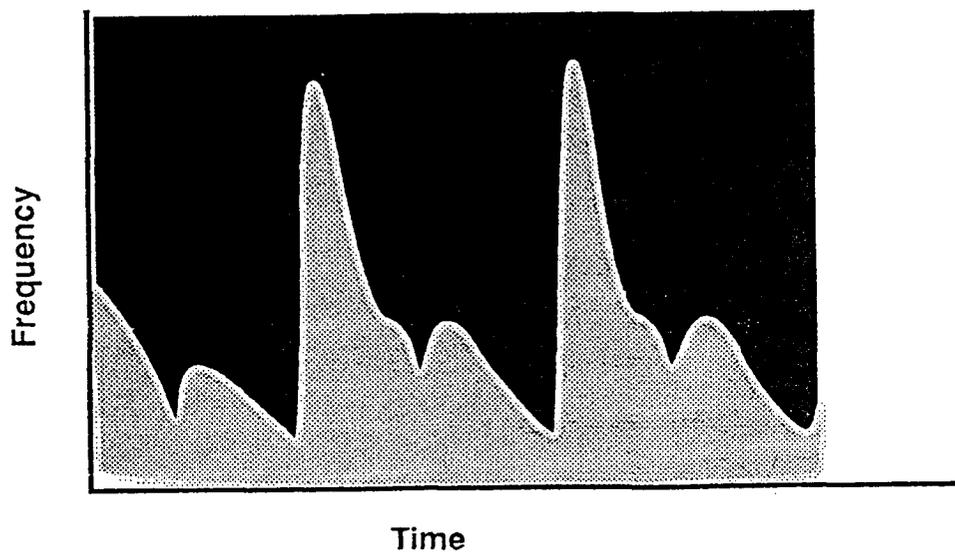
Doppler Tracing: External Carotid Artery
